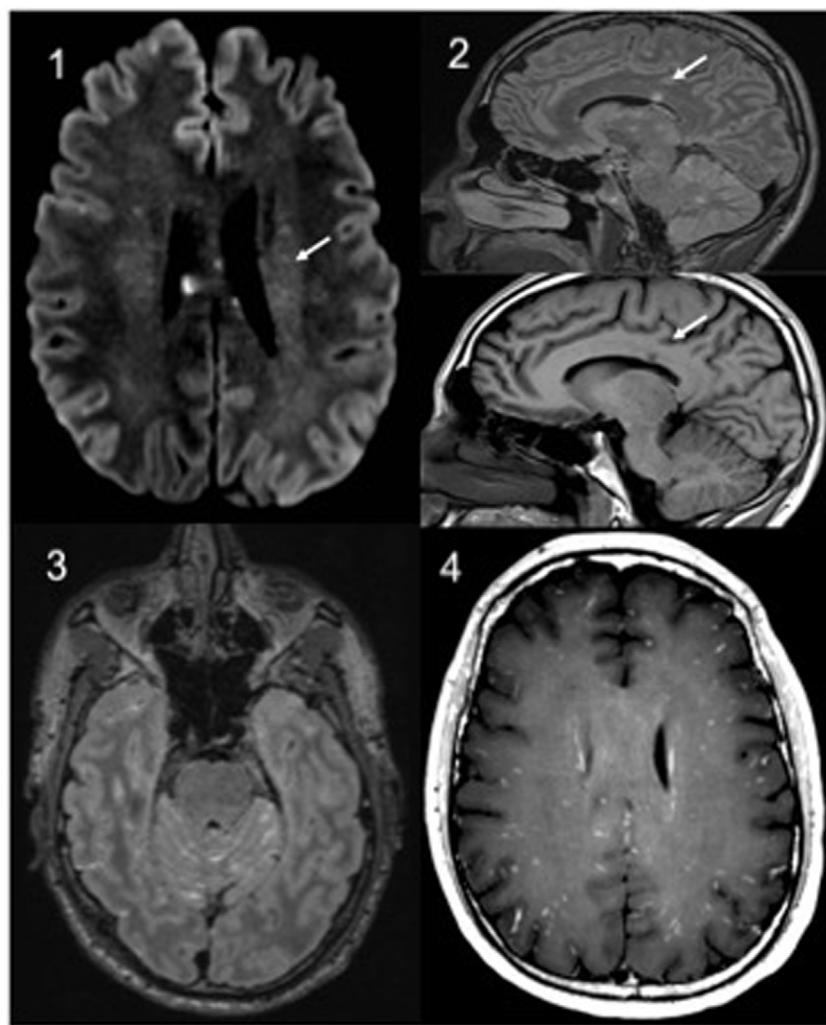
Brain MRI: 1: Axial. Diffusion with hyperintense punctiform lesions in relation to microinfarcts. 2: Sagittal, T2 Flair and T1 sagittal. Characteristic involvement of the corpus callosum. 3: Axial T2 Flair with contrast. hypersignal and leptomeningeal enhancement (additive signal T1 contrast +T2). 4: Axial T1 contrast with "military" uptake pattern.
